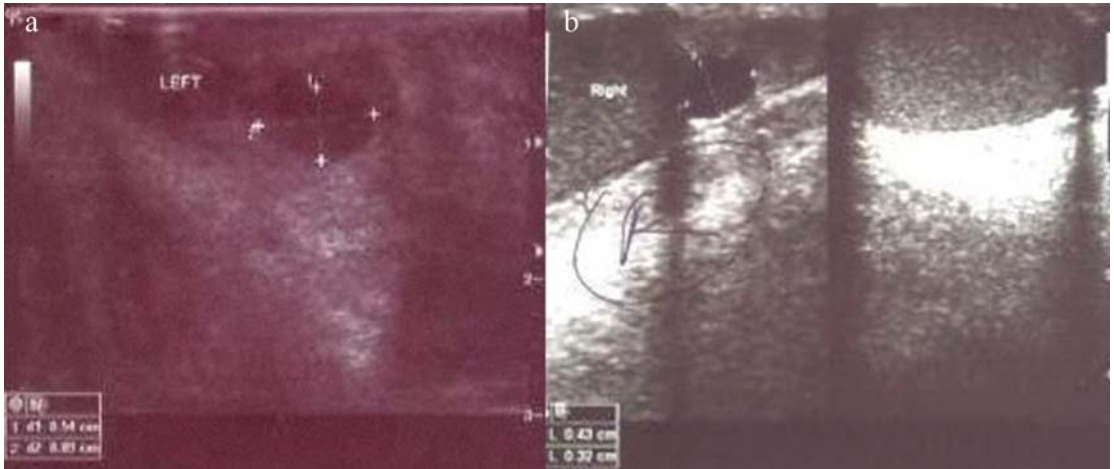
Ultrasonographic view of epididymal cyst. a. On the left side, left epididymal cyst size 9x7mm, b. On the right side right epididymal cyst size 4,5x3mm.
